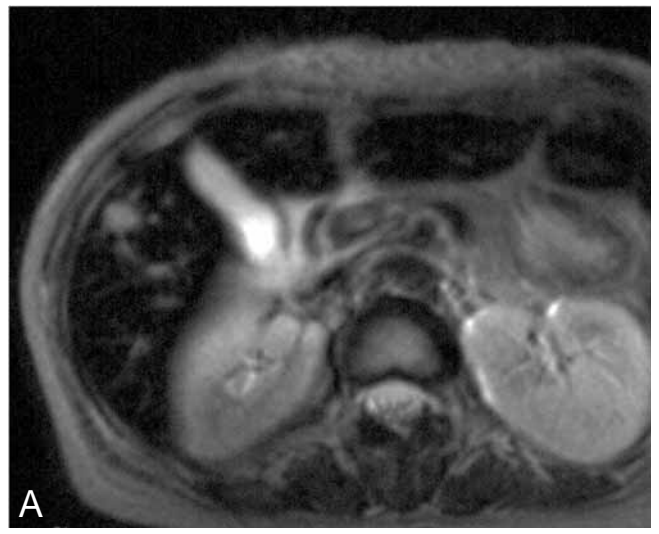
Liver hemangioma. On T2-weighted images, the lesion, located in segment V, is hyperintense (A). On T1-WI image, the lesion is isointense (B), and appears hyperintense related to the surrounding liver after SPIO particles injection, due to a vascular effect.
